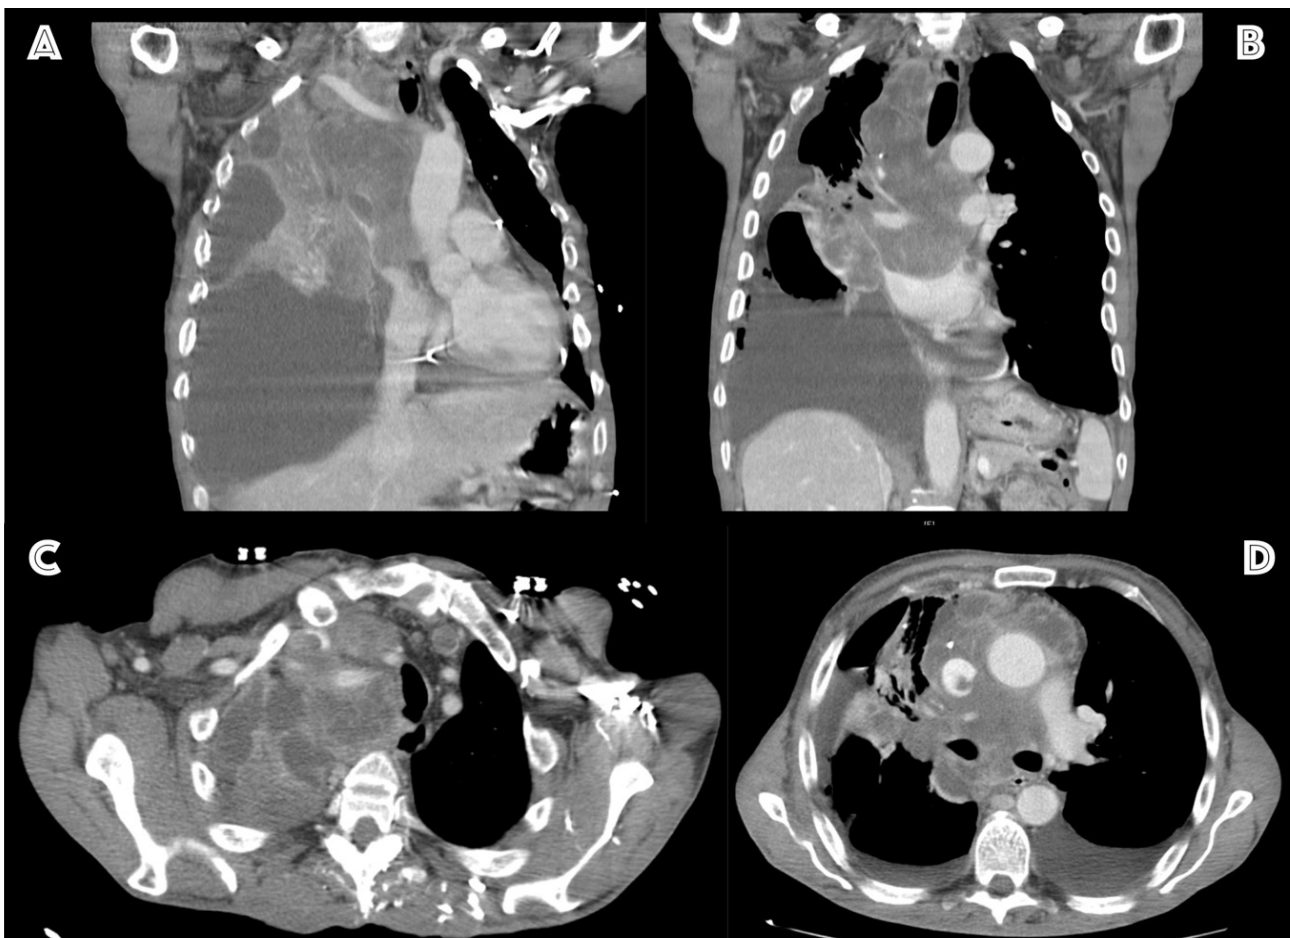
CT scan in emergency room, after pericardiocentesis, showing A) right pleural effusion and a large, heterogeneous and necrotic mediastinal mass, with deviation of the trachea as well as compression of the left atrium and an apparent plane of continuity with the pericardium (B, C and D).
